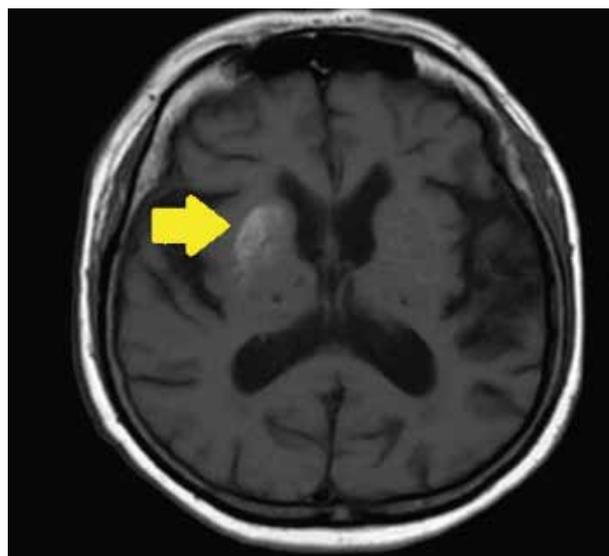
MRI brain showing T1 hyperintensity of right putamen
